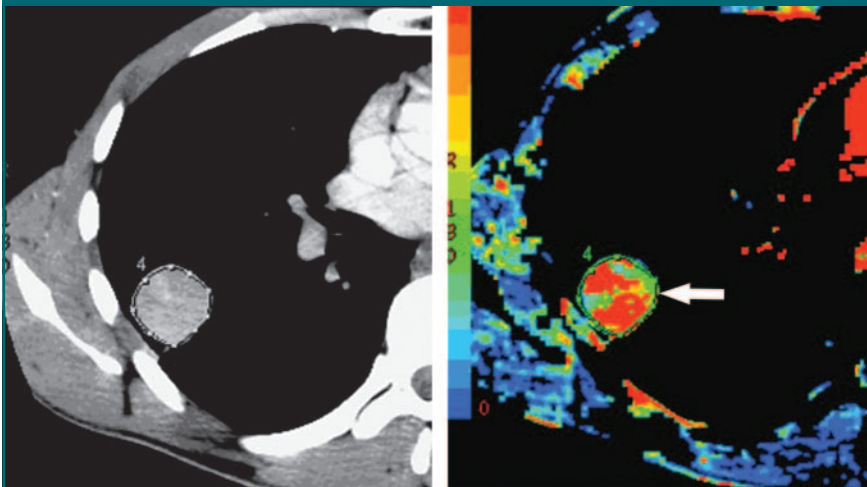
(a) Transverse contrast-enhanced CT image and (b) functional CT perfusion map of BF in 28-year-old man with lung metastasis (arrow) from HCC show high BF compared with adjacent muscle.
